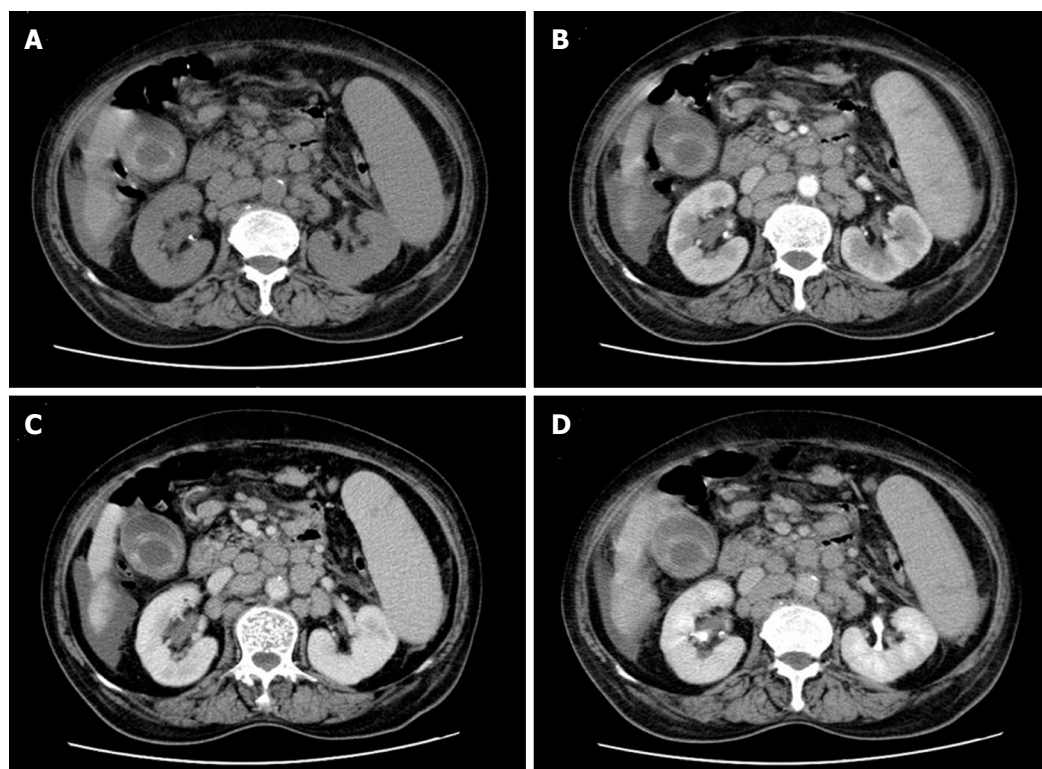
Abdominal computed tomography scan revealed a fuzzy peritoneal cavity and multiple enlarged portal peripheral lymph nodes with cholecystitis. A: Plain computed tomography (CT) scan image; B: CT image in the arterial phase of contrast enhancement; C: CT image in the portal venous phase of contrast enhancement; D: CT image in the parenchymal phase of contrast enhancement.
